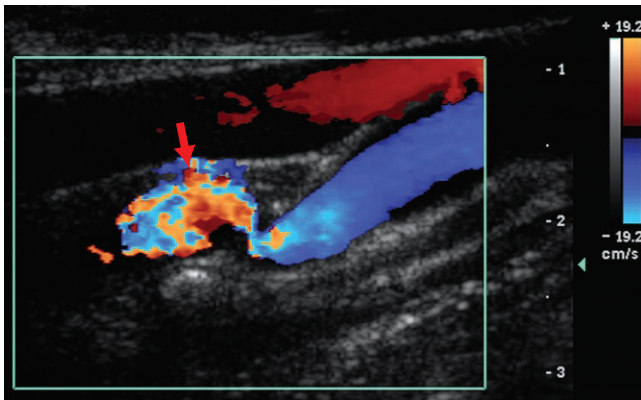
Color Doppler of the mid internal carotid artery in a patient with carotid fibromuscular dysplasia demonstrates angulation of the vessel and aliasing after the narrowing (arrow).
